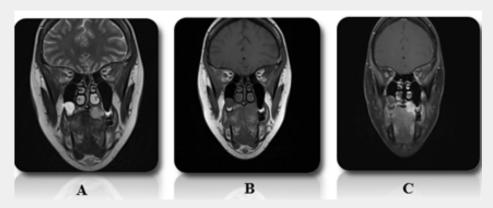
Coronal (A) T2 weighted and (B) T1 weighted MR images demonstrate a well-defined lesion along the left hard palate that hyperintense on T2 and isointense to muscle on T1, mild smooth remodeling of bone adjacent to lesion.
